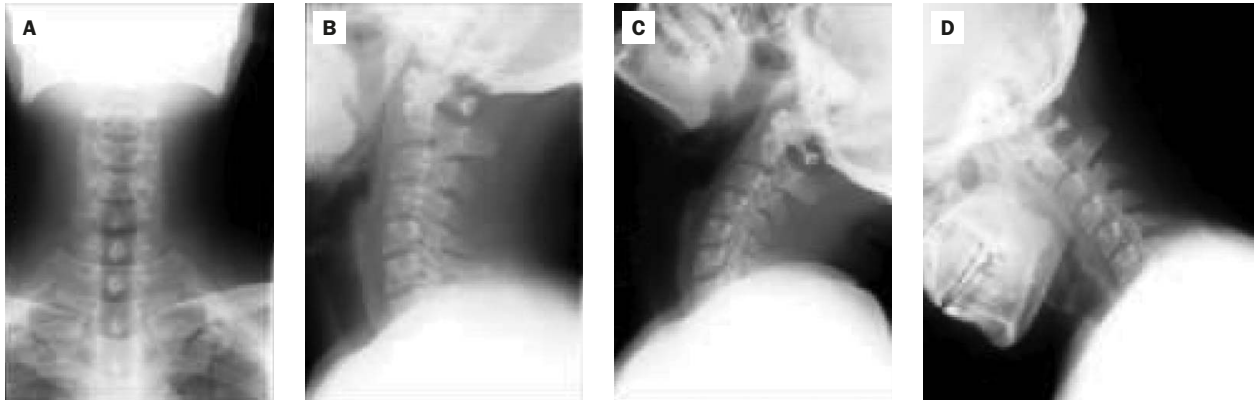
Plain cervical X-ray reveals mild degenerative change without significant instability.
